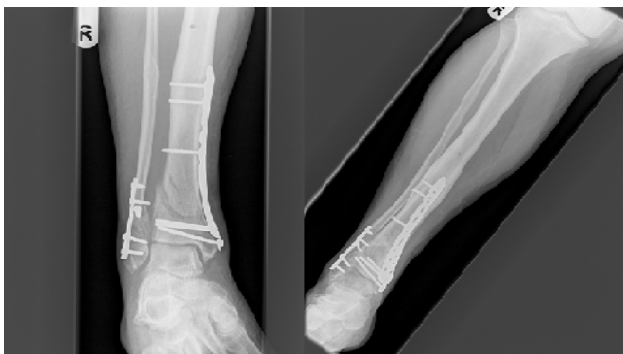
X-rays pre and post LIPUS.
